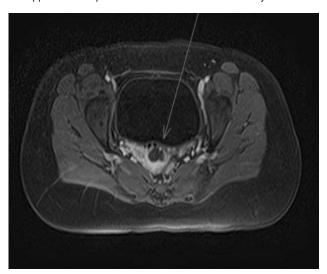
2 weeks later further episode of bleeding which was investigated with MRI showing pseudo-aneurysm.
